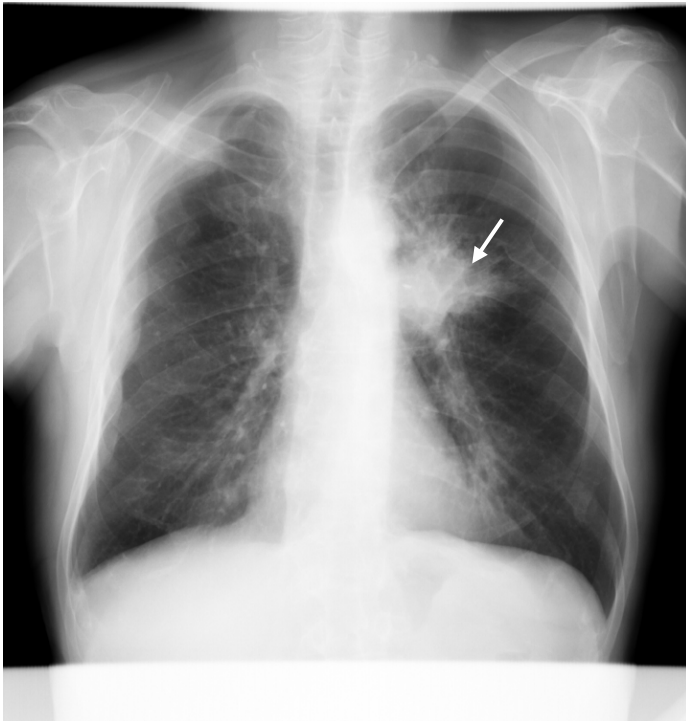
Chest radiograph. In the middle zone of the left lung there is a limited shadow of average intensity with not distinct contours (arrow). Acute pneumonia in the third segment of left upper lobe
